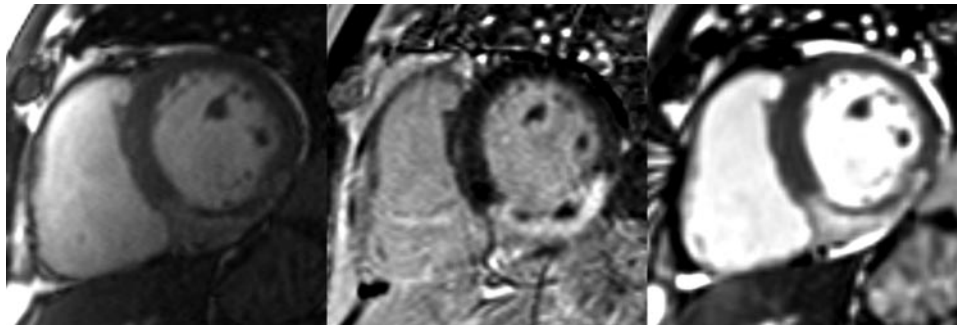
Matched diastolic cardiac MRI (left, cine MRI; middle, phase-sensitive inversion-recovery image; right, T2-weighted SSFP) obtained in a 57-year-old man 1 week after primary PCI to the right coronary artery for an acute inferior STEMI. Post-PCI culprit artery flow was reduced (TIMI flow grade 1). Transmurular infarction (as revealed by late gadolinium enhancement, middle) corresponds to transmurular edema (bright-blood, T2-weighted SSFP, right). Absolute AAR and salvage in this patient were 29% and 6%, respectively. The central dark zones within the infarct territory represent MVO complicated by hemorrhage.²⁸
